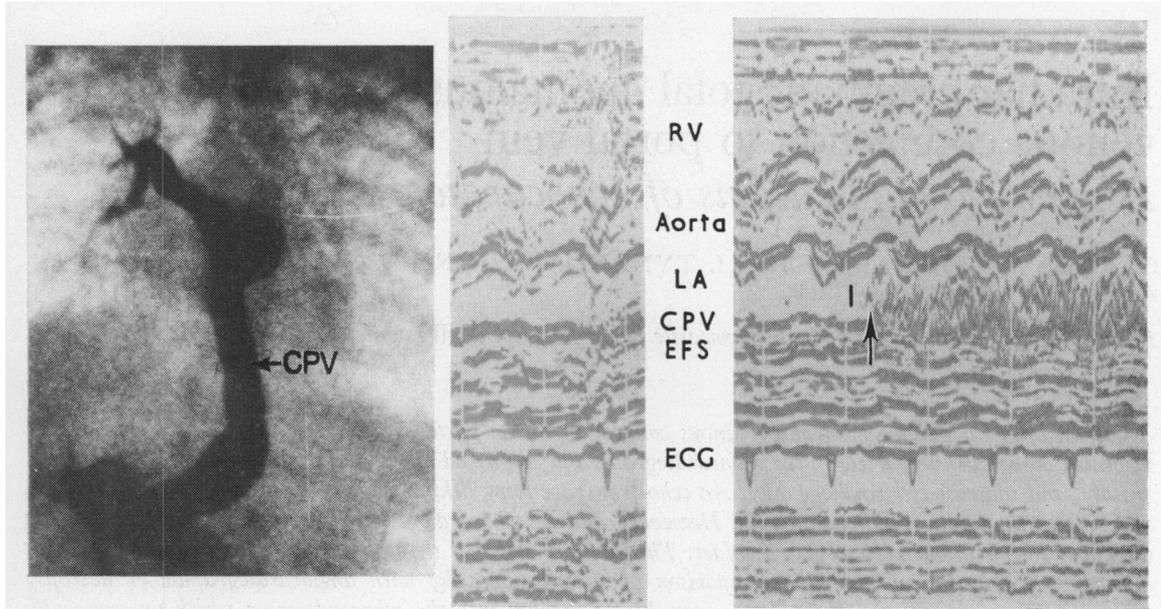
Angiogram into the common pulmonary vein (left) with initial echocardiogram (centre) and contrast echocardiogram (right). RV, right ventricle; LA, left atrium; CPV, common pulmonary vein; EFS, echo free space; I, injection of dextrose.
